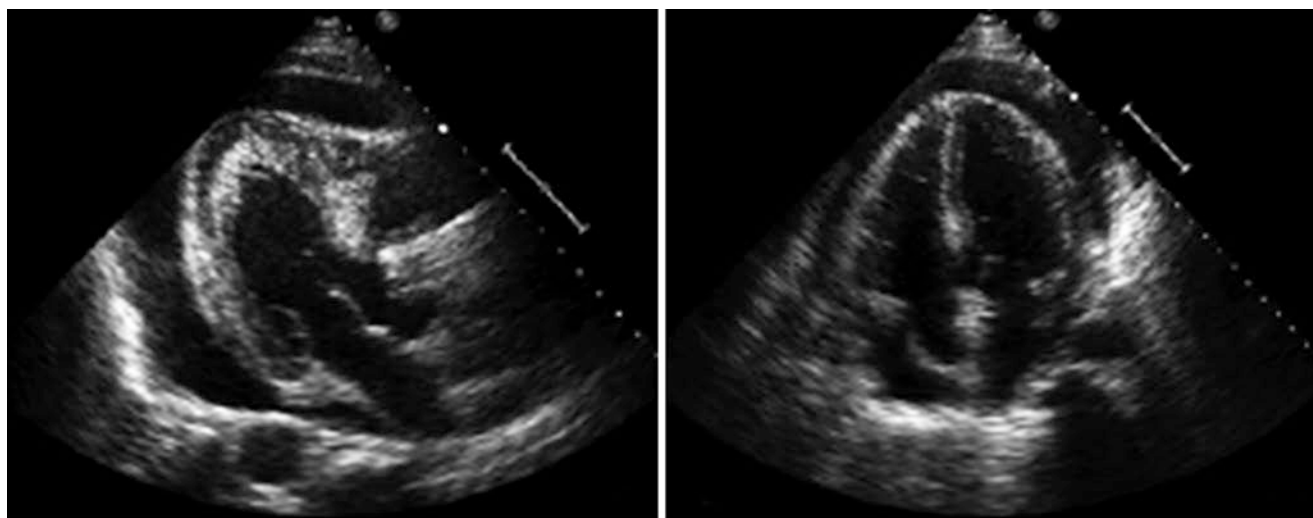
Echocardiographic four-chamber and long-axis view showing moderate pericardial effusion
